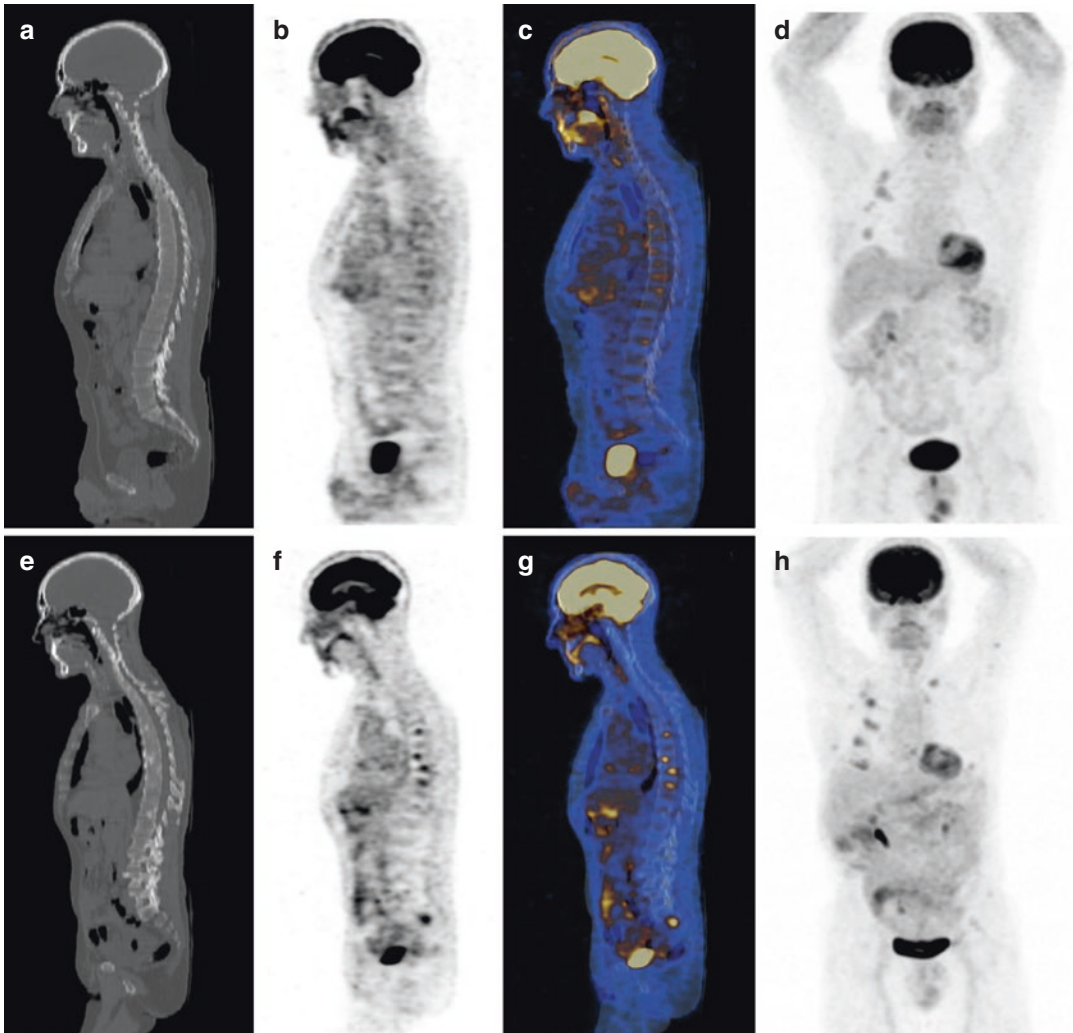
Serial [18F]FDG PET/CT scans of a 62-year-old male patient with radioiodine-negative metastasized poorly differentiated thyroid carcinoma before (a–d) as well as at 24 months (e–h) after the start of TKI therapy (lenvatinib, 10 mg daily). Previously, the patients underwent thyroidectomy (pT3N1M1), radioiodine ablation (3.7 GBq), and PRRT (17.0 MBq of ¹⁷⁷Lu-DOTATATE and 4.8 MBq of ⁹⁰Y-DOTATATE). The follow-up PET/
